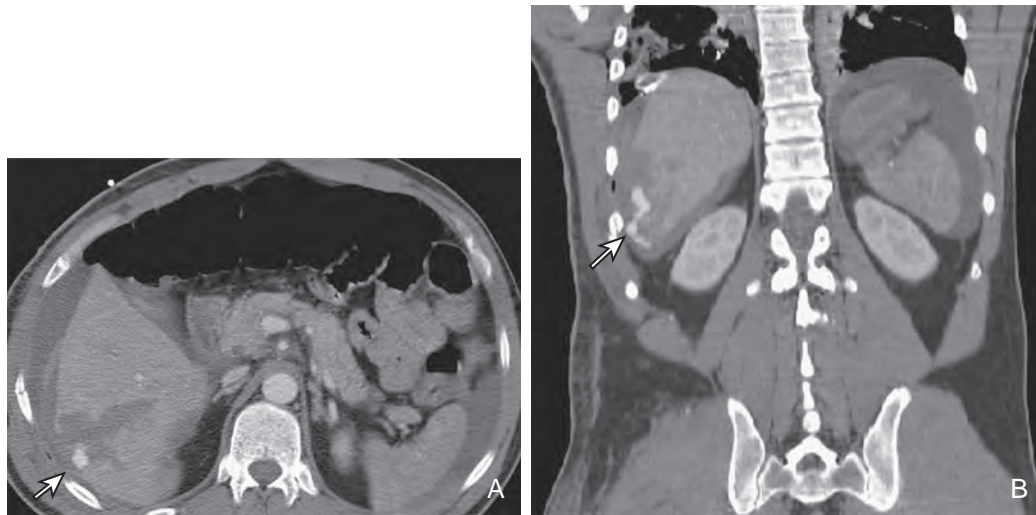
Hepatic laceration with active extravasation. A. CT shows a low-density laceration in the posterior segment of the right hepatic lobe. Focal hyperdensity consistent with active extravasation of contrast material and active hemorrhage is seen (arrow). B. A coronal reformatted image further reveals the extent of active extravasation (arrow). High-density fluid in the peritoneal cavity is consistent with hemoperitoneum.
